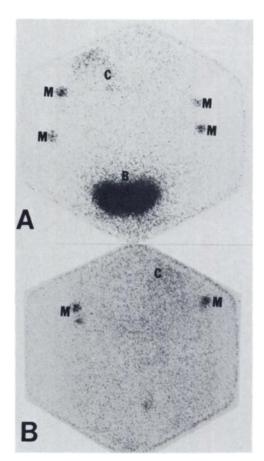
A. Anterior pelvic scintigram showing prominent I-131 MIBG bladder activity (B). Colonic activity is also seen (C). B. Anterior pelvic scintigram after catheterization and drainage of bladder. Little bladder activity remains. M indicates radioactive markers.
